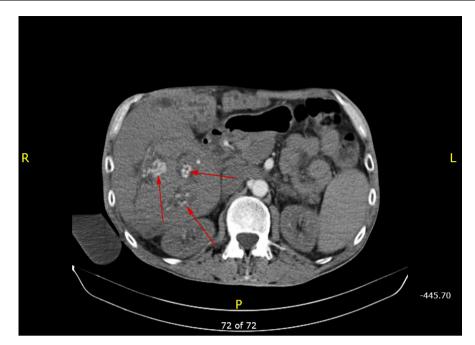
Computed tomography of the abdomen - dilated intrahepatic bile ducts filled with multiple calculi - a sign of "pearls"
